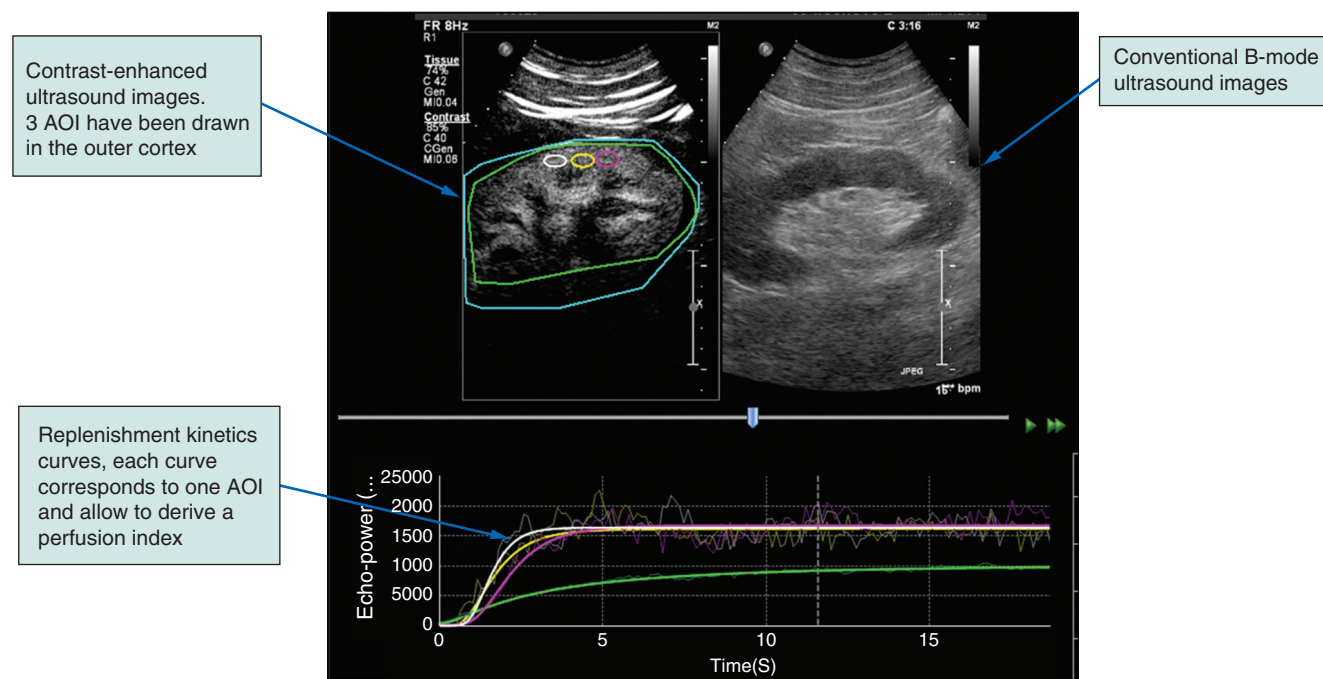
See also color plates. Renal perfusion index measurement using dedicated quantification software (Screenshot). Screenshot of Sonotumor™, shown as an example of software allowing perfusion quantification in CEUS sequences. The *upper segments* show the contrast-enhanced images (*left*) as well as the conventional ultrasound images (*right*). This is where the reader can draw an area of interest (AOI) that will be analyzed by the software. Replenishment curves (*lower segment*) then are generated for each AOI. These curves represent the intensity of the echo-power as a function of time after the flash. *Bold lines* are fitted curves of the actual measured data represented by the clear lines. The fitted curves allow the derivation of a perfusion index (PI) for each AOI. (Modified from Schneider A, Johnson L, Goodwin M, et al. Bench-to-bedside review: contrast enhanced ultrasonography—a promising technique to assess renal perfusion in the ICU. *Crit Care*. 2011;15(3):157.)
